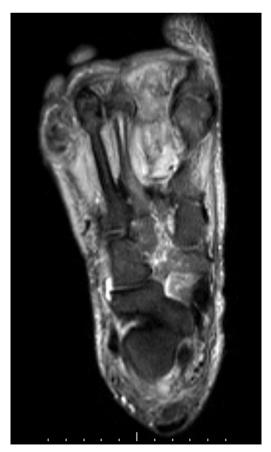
MRI: soft tissue swelling and atrophy of the plantar muscles
